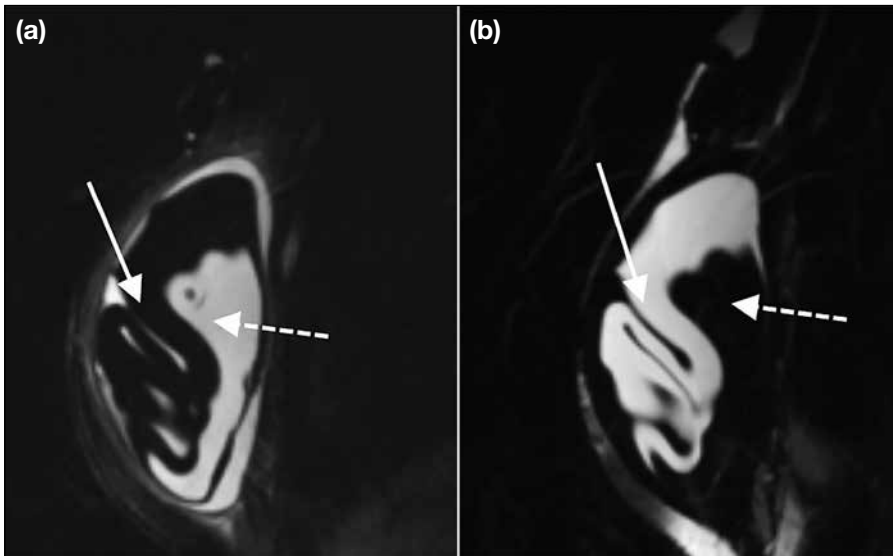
Inverse double-lumen implant (outer silicone layer and inner saline component) complicated by intracapsular rupture. Note the characteristic signals of silicone and saline on the magnetic resonance imaging (MRI) sequences. (a) In T2-weighted fat-suppressed silicone-suppressed MRI, the outer silicone layer (solid arrow) shows hypointense signal and inner saline layer (dashed arrow) shows hyperintense signal. (b) In T2-weighted saline-suppressed MRI, the outer silicone layer (solid arrow) shows hyperintense signal and inner saline layer (dashed arrow) shows hypointense signal. Note the wavy appearance of the silicone material (solid arrow), which is confined within the fibrous capsule with no evidence of extracapsular leakage.
